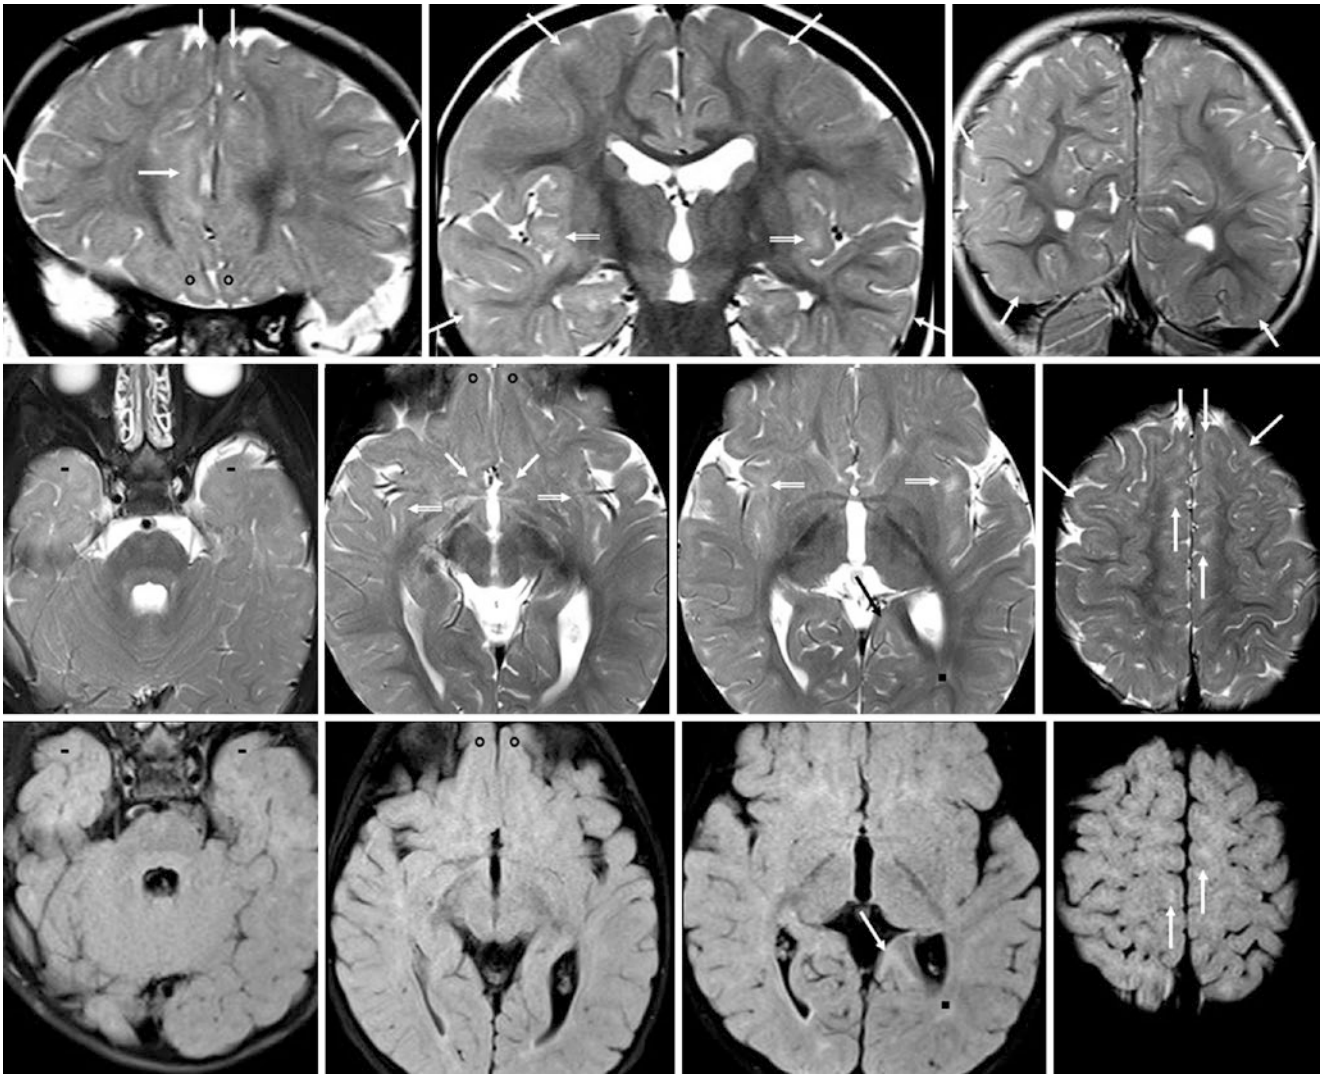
Top row:* a 14.5-month-old with motor delays had a normal 3T MRI with coronal SE T2WIs. Note hyperintense, patchy SCWM foci (*thin arrows*), which are most prominent anteriorly and inferiorly in the frontal and temporal lobes. *Second row:* On axial SE T2WIs, note that the PVWM is relatively mature, with the exception of terminal zones in the periaxial WM (*squares*) and SIWM (*beveled arrows*). Note
